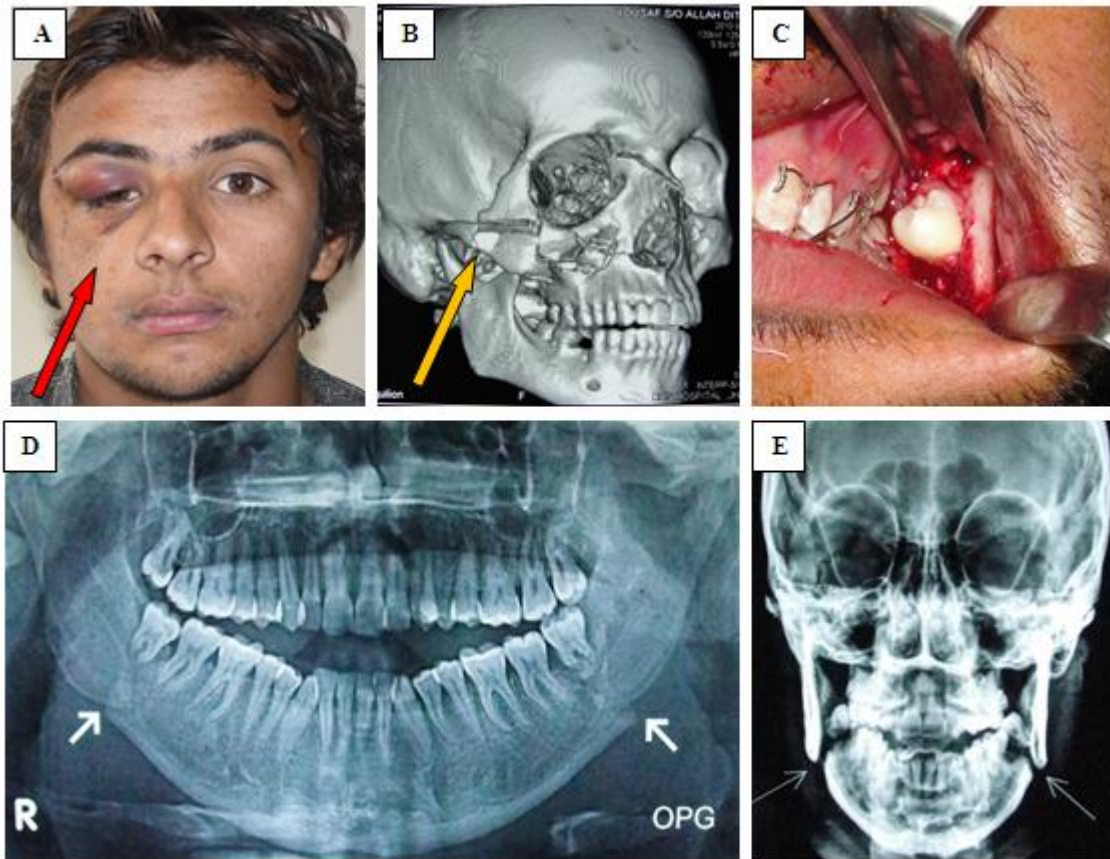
A. Malar Flattening and Upper Eye Lid Swelling in Patient of Right Zygomatic Bone Fracture (red arrow). B. Zygomatico-maxillary Complex Bone Fracture in 3- D Reconstruction CT Scan of Face (orange arrow). C. Per-operative View of Left Mandibular Angle Fracture. D. Bilateral Mandibular Angle Fracture on Panoramic View (white arrows). E. Bilateral Mandibular Angle Fracture on Frontal View.
